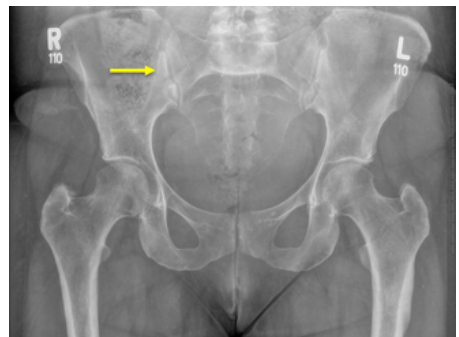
Pelvic X-Ray (September 2023): Minimal sclerosis on the right sacroiliac joint demonstrated (yellow arrow). There is no evidence of definite radiographic sacroiliitis.
